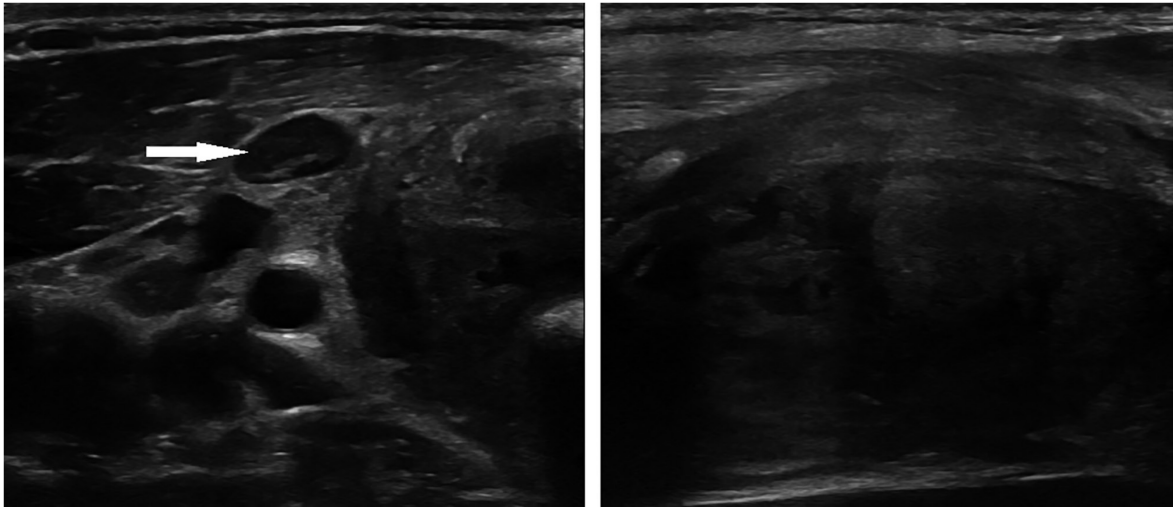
Sonography of the right thyroid lobe at initial presentation of the patient (left image: transverse axis, right image: sagittal axis, arrow: prominent lymph node). Images in this figure were published by Trummer, Theiler-Schwetz, and Pilz [105] and Trummer et al. [2] under the CC BY license.
